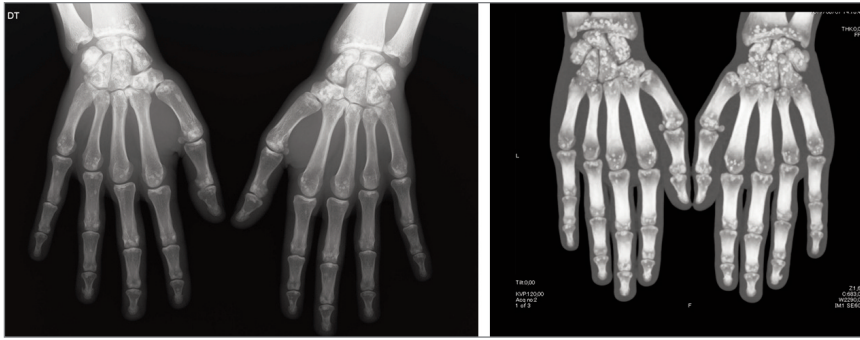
Hands AP radiography and computed tomography (case 2)
